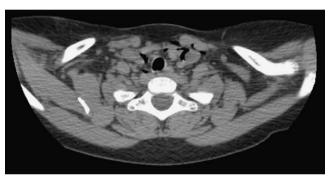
CT: mediastinal emphysema.
